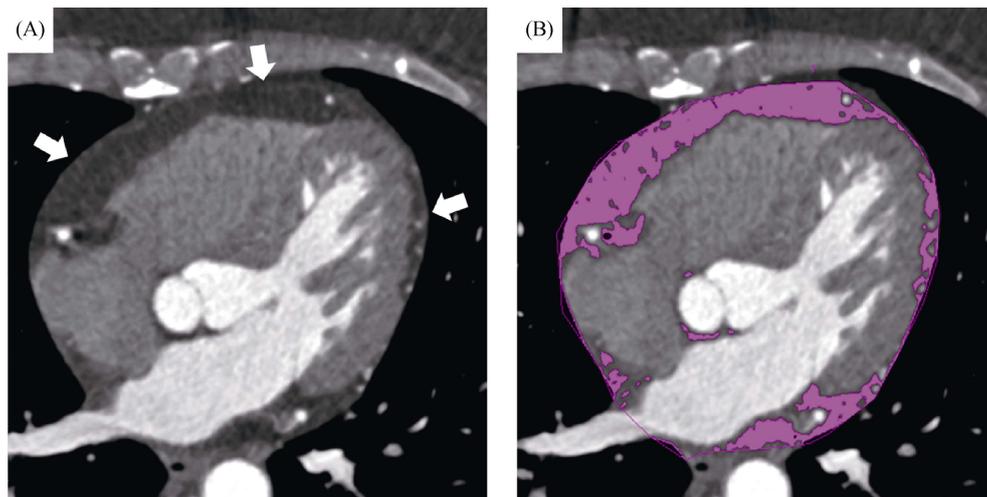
Example of EAT volume quantification by CCTA. (A): EAT was defined as the adipose tissue within the visceral layer of the pericardium (arrows on A); (B): Total EAT volume was quantified by manually tracing the pericardium on the contrast-enhanced CT imaging, then calculated and highlighted with a threshold of -30 to -190 HU by the software (Syngo Volume, Siemens Medical Solutions). Purple area represent EAT. CCTA: coronary computed tomography angiography; EAT: epicardial adipose tissue.
